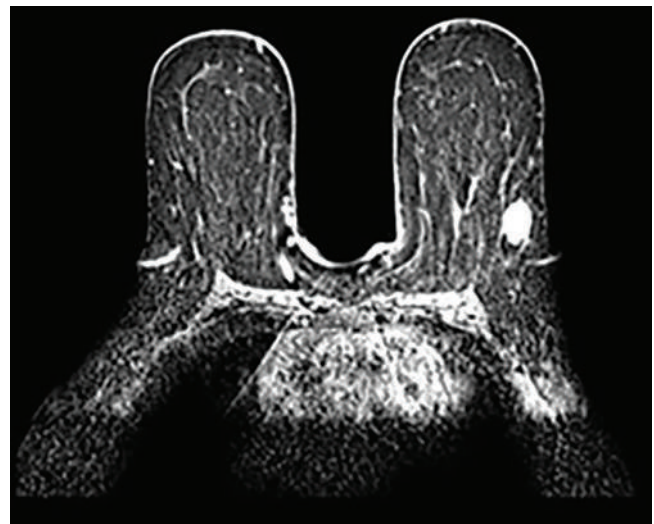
Left breast mass, breast MRI.
